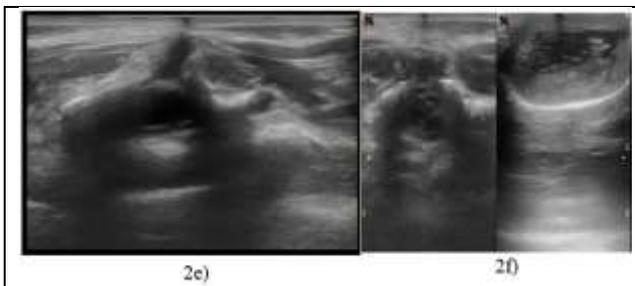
Axial Ultrasound Demonstrates Divergence of the Posterior Arches at the Site of the Osseous Defect
